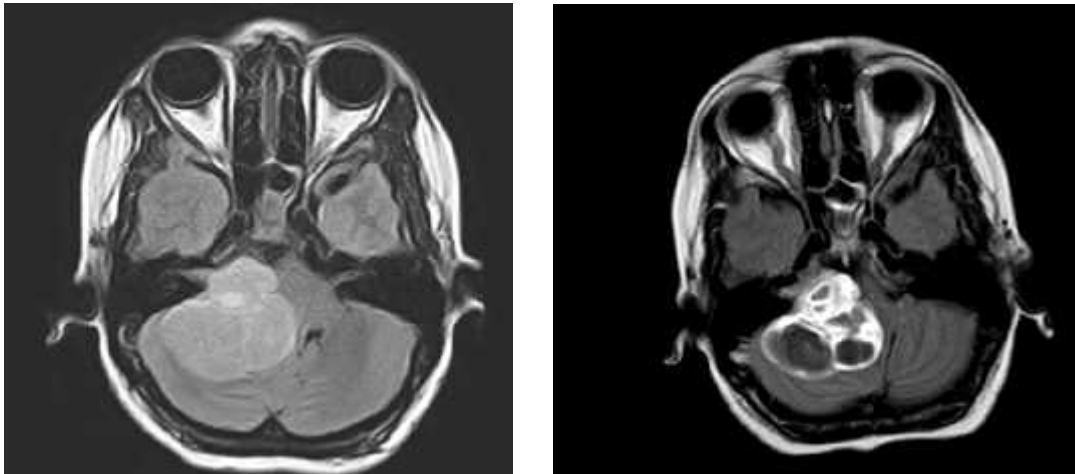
On MRI it appears heterogenous signal intensity on T2 FLAIR with few cystic components image in right cerebellopontine angle. On Post Contrast T1 axial study it is showing heterogenous enhancement of intra and extra canicular segments and trumpeted internal auditory canal suggestive of acoustic neuroma.
